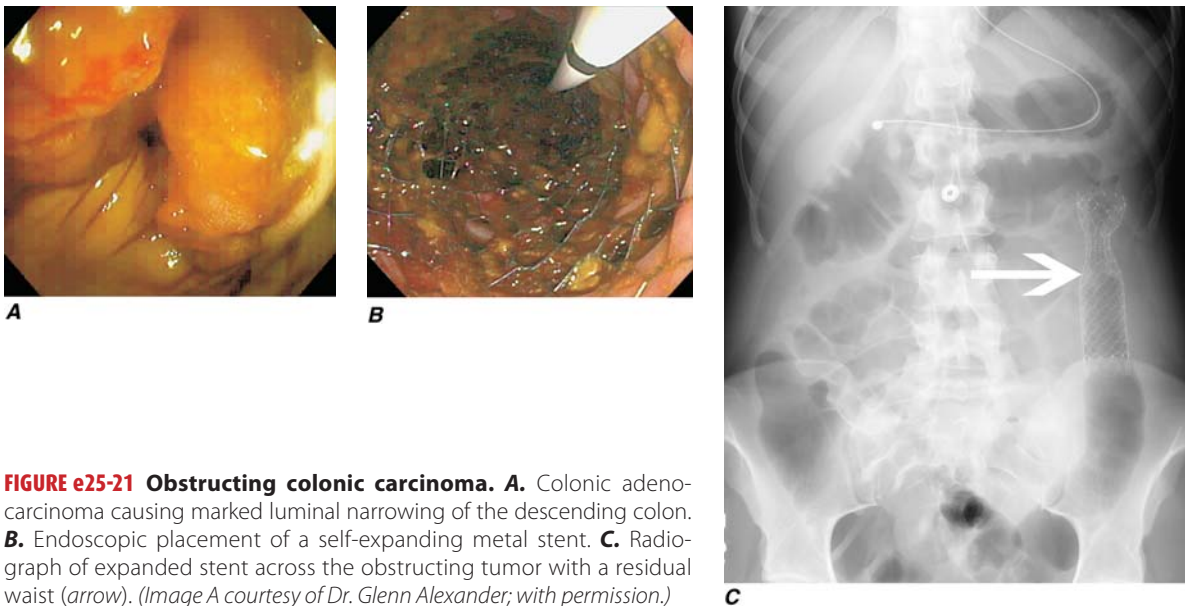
FIGURE e25-21 Obstructing colonic carcinoma. A. Colonic adenocarcinoma causing marked luminal narrowing of the descending colon. B. Endoscopic placement of a self-expanding metal stent. C. Radiograph of expanded stent across the obstructing tumor with a residual waist (arrow). (Image A courtesy of Dr. Glenn Alexander; with permission.)
